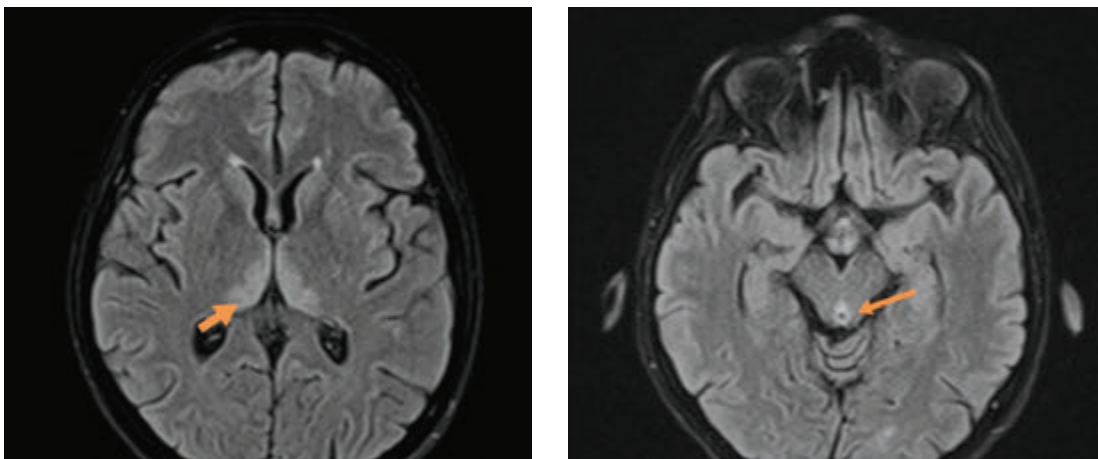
Presentation of hyperintensities in thalami and periaqueductal areas on MRI brain in T2/FLAIR sequence.
